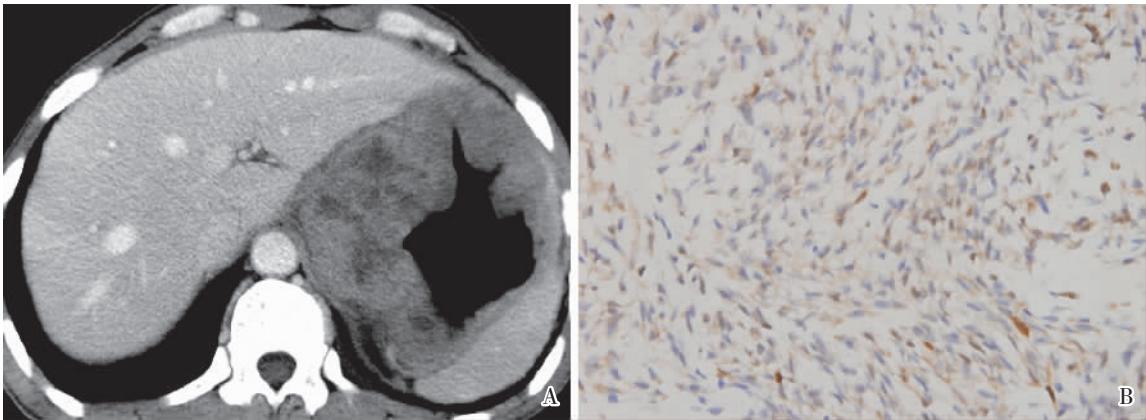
CT features and morphology of S100-positive GIST
